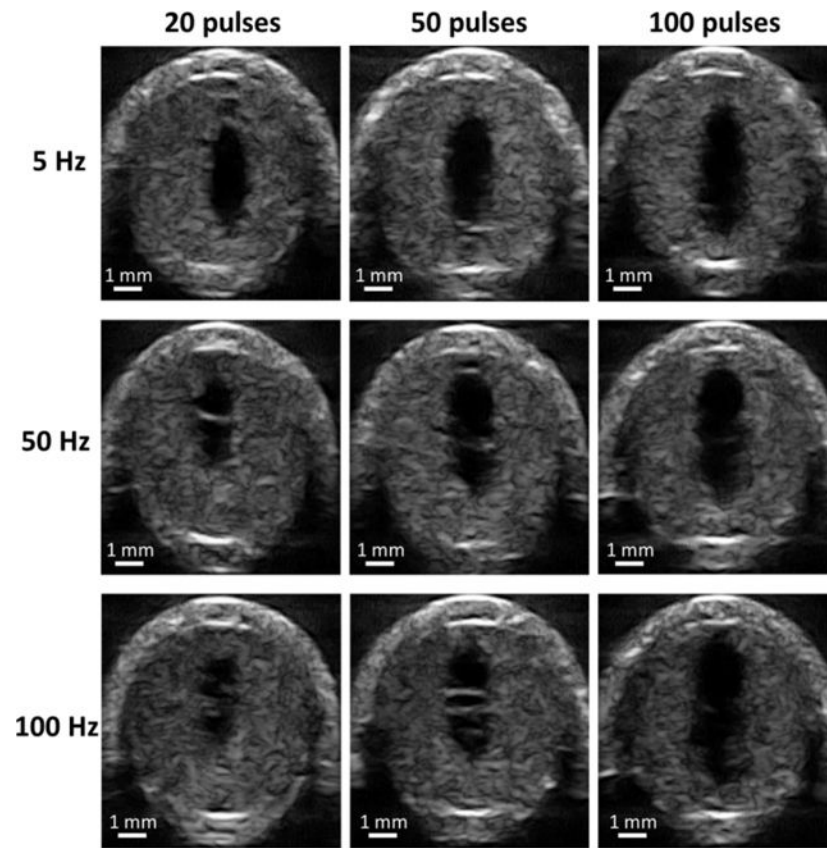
Representative high-resolution ultrasound images of flow channel generated from each treatment parameter combination. The generated flow channels show as the hypoechoic zones inside clots. Ultrasound propagated from the top to the bottom of the images.
